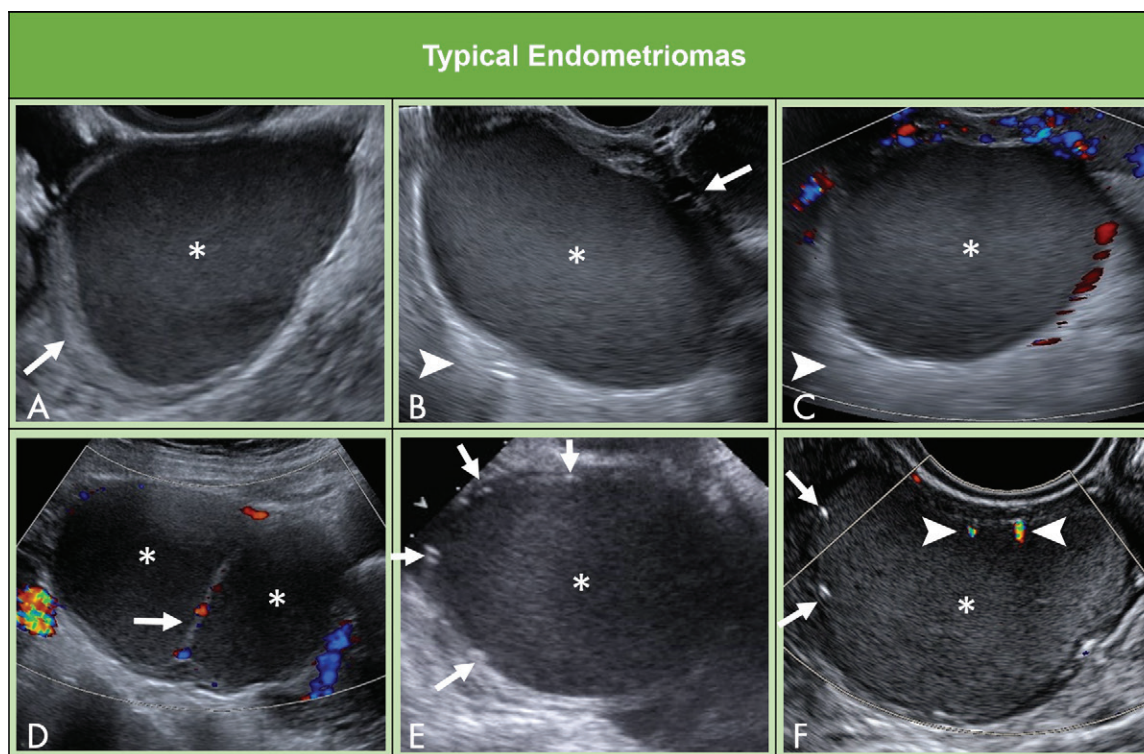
Images show typical endometriomas. A, Common appearance of endometrioma demonstrates homogenous low-level or ground glass internal echoes (asterisk); surrounding ovarian parenchyma (arrow) is seen. B, Similar features of homogenous low-level or ground glass echoes (asterisk) with surrounding ovarian tissue (arrow) and posterior acoustic enhancement (arrowhead). C, No internal flow at Doppler imaging should be observed in endometriomas; homogenous low-level echoes (asterisk) and posterior acoustic enhancement (arrowhead). D, Multiloculated endometrioma with homogenous low-level echoes (asterisks) in each component; flow may be observed in intervening septum (arrow). E, Occasionally, peripheral punctate echogenic foci (arrows) are seen with endometriomas; however, homogenous low-level echoes (asterisk) are most specific feature. F, Although shadowing is typically not associated with peripheral punctate echogenic foci (arrows) surrounding endometrioma (asterisk), twinkling artifacts may be appreciated with Doppler imaging (arrowheads).
